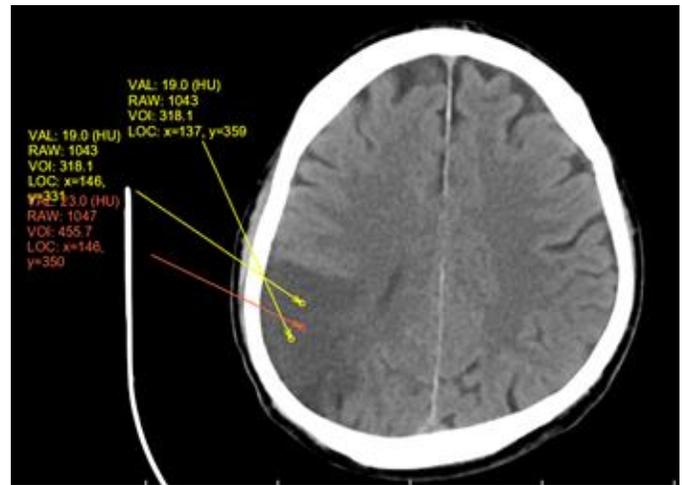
Representative subacute ischemic infarction on CT
